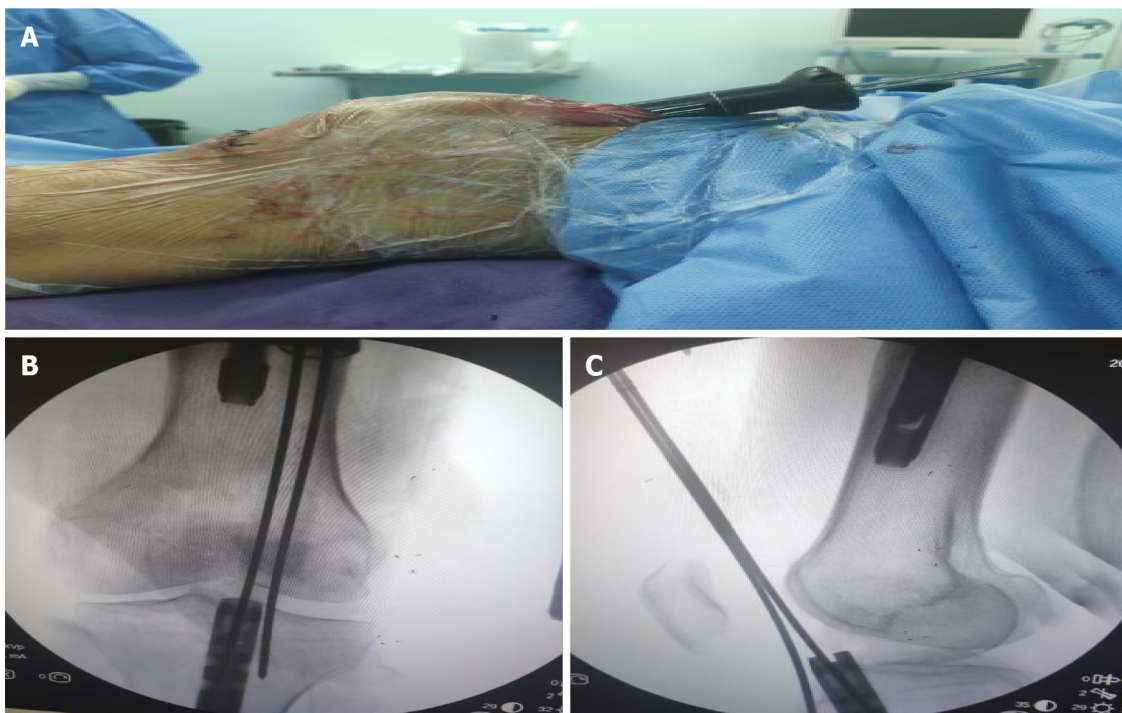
Insertion of the guide needle through the nail. A: The guide needle was inserted through the nail *via* the suprapatellar approach and was assisted by a multi-holed guide pin sleeve; B: Antero-posterior X-ray view showing insertion of the guide needle into the cavity of the intramedullary nail; C: Lateral X-ray view showing insertion of the guide needle into the cavity of the intramedullary nail.
